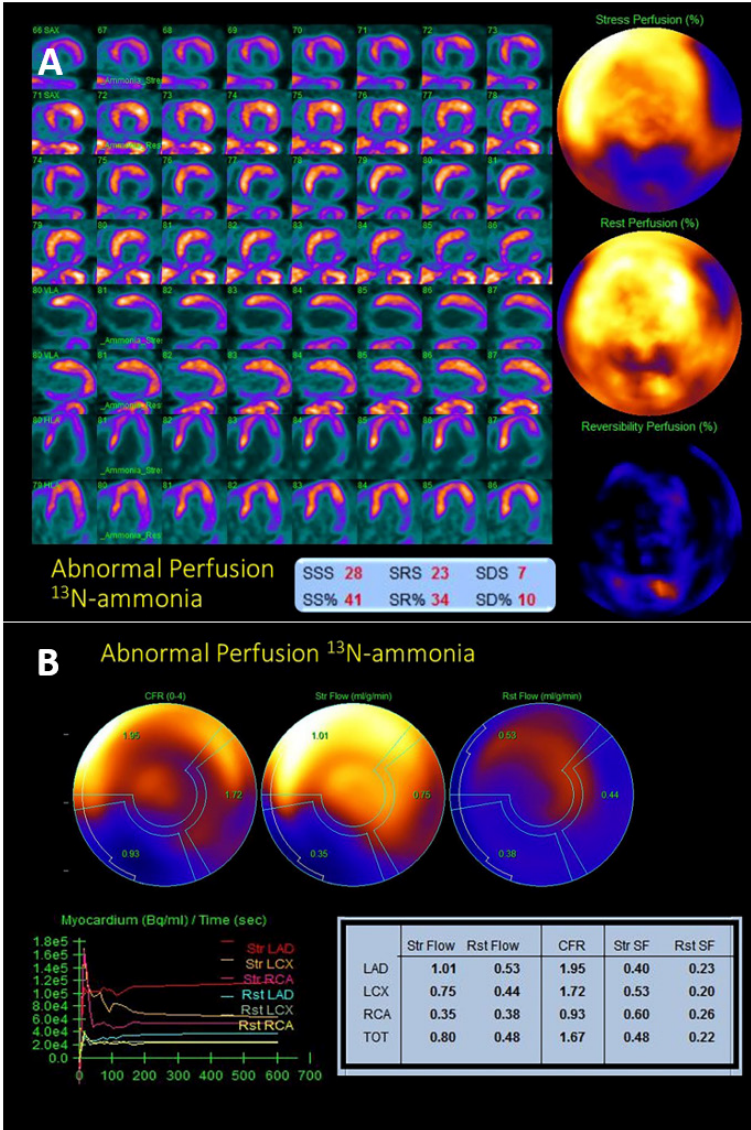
Abnormal perfusion detected with ^{13}N ammonia PET-CT. (A) The study shows an abnormal myocardial perfusion with severe inferior wall defect with moderate reversibility. The same pattern is shown for the lateral wall where the defect is only partially reversible, with a posterolateral area of possible limited scar. The summed difference score is 10%. (B) Quantification shows severely diminished MBF in the territory of the right coronary artery with the lower CFR. The left circumflex artery and the left anterior descending artery are also affected. The study is compatible with triple vessel disease.
